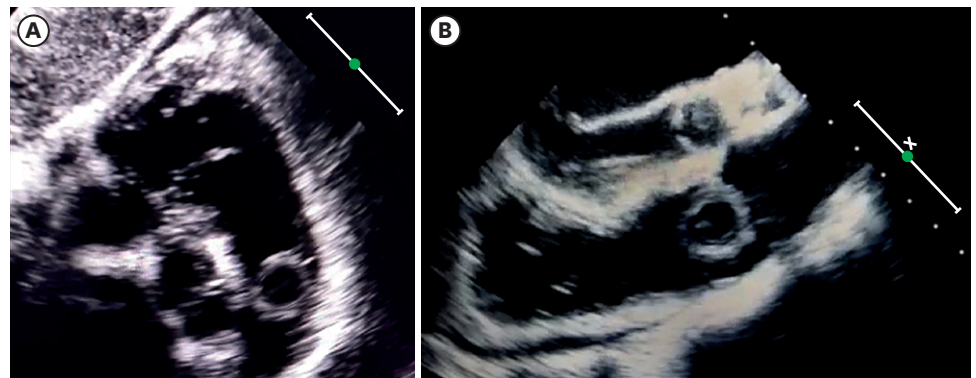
Echocardiographic evaluation. The transthoracic echocardiography confirmed the presence of the mass, attached to the ventricular side of the PV, resulting in mild valve obstruction. The mass showed an anechoic content surrounded by a hyperechoic structure, suggesting the cystic nature of the mass (A); those findings were confirmed by transesophageal echocardiography (B). PV: pulmonary valve.
